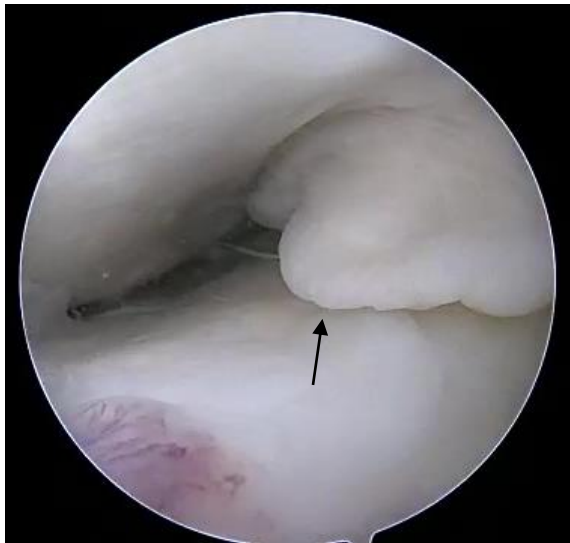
Image showing MRI finding of partial ACL tear (red arrows). Arthroscopy (black arrows) showed chronic complete ACL tear
